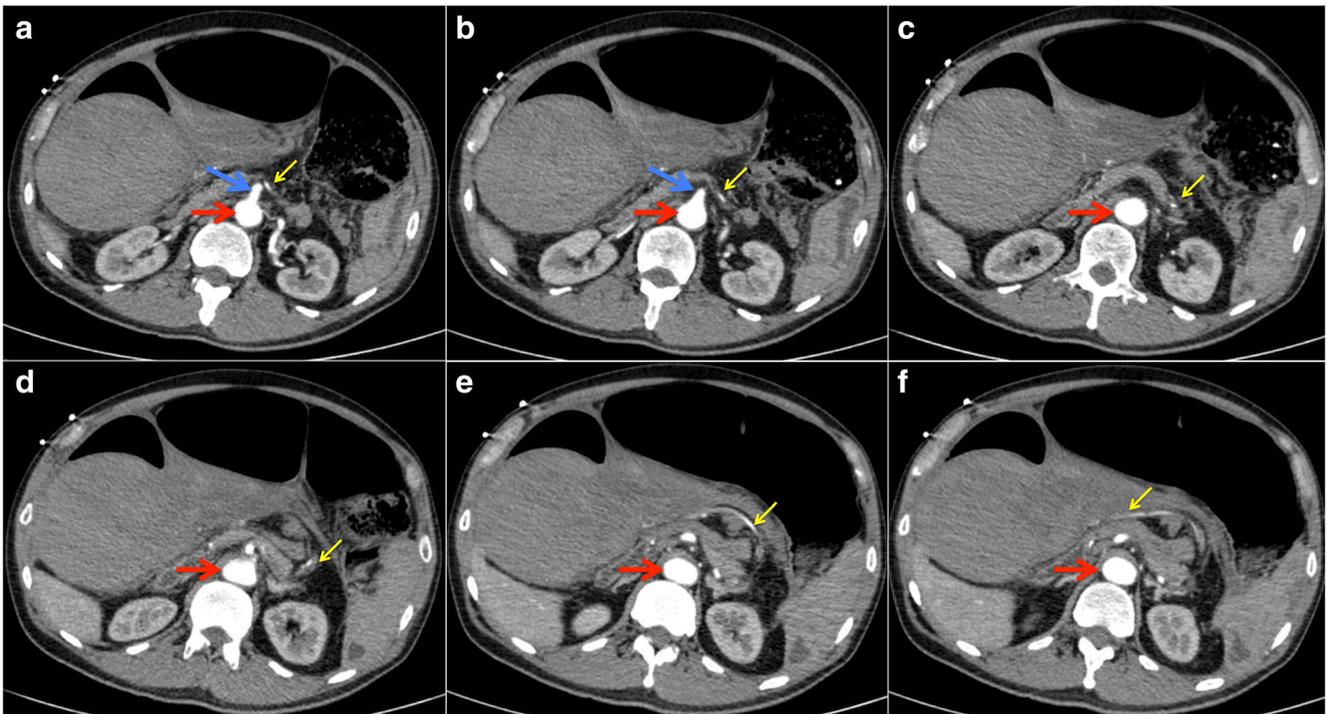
CT images showing sequential axial cuts in a caudo-cephalad direction depicting the aorta (red arrow), superior mesenteric artery (blue arrow) and middle colic artery (yellow arrow)
